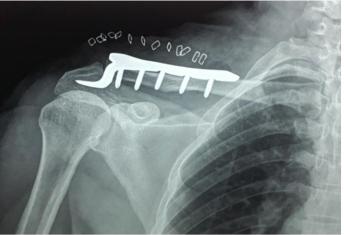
Image showing post-operative X-ray after hook plate fixation
